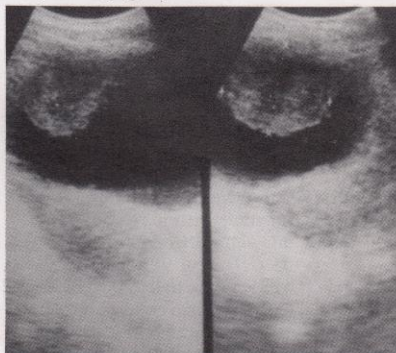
Ultrasonogram confirmed a well-defined intravesical mass.
